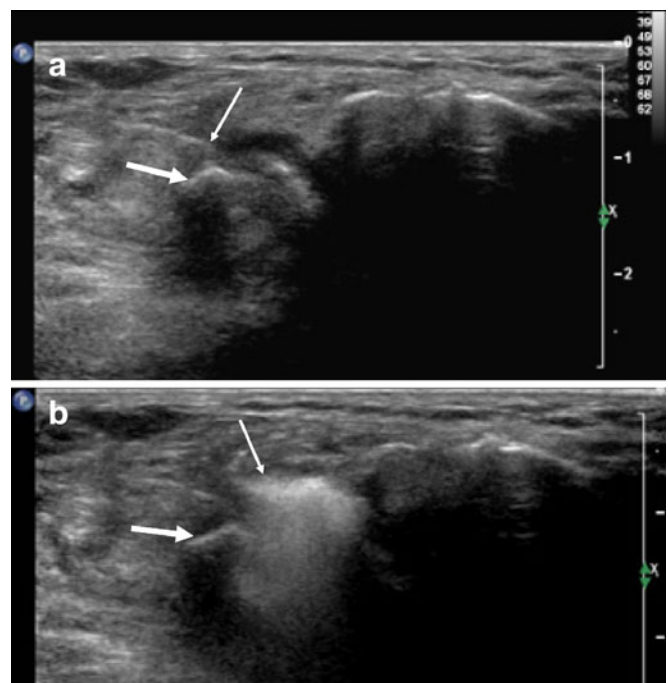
An example of an ultrasound-guided steroid/anesthetic injection around the os is shown. The linear hyperechoic needle tip (*thin white arrow*) is directly adjacent to the os peroneum (*thick white arrow*) (a). Injection of the steroid/anesthesia mixture preferentially fills an adventitial bursa around the os (*thin white arrow*). The os is still partially visible (*thick white arrow*) (b)
